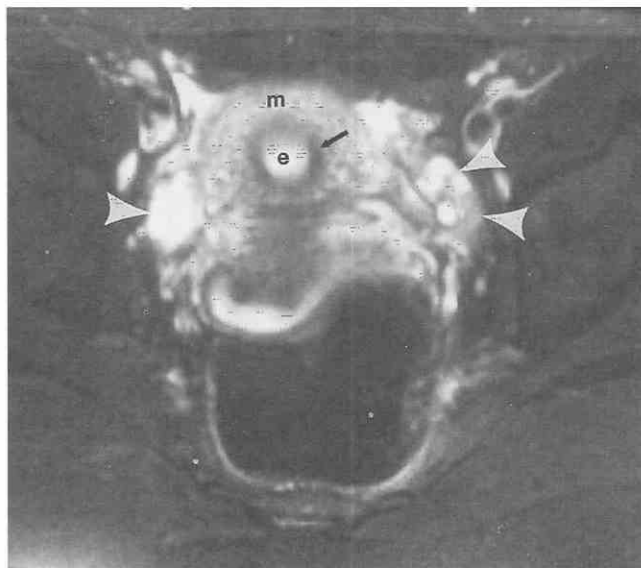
Normal postmenarchal female pelvis. T2-weighted fat-saturated (3500/98/180 degrees) MR image of a 14-year-old girl demonstrates that both ovaries have relatively high signal intensity (arrowheads), reflecting the presence of multiple follicles. Some intermediate-signal-intensity stromal tissue can be noted in the left ovary posteriorly. Note the zonal anatomy of the uterus. e, endometrial canal; m, myometrium. Arrow indicates junctional zone.
